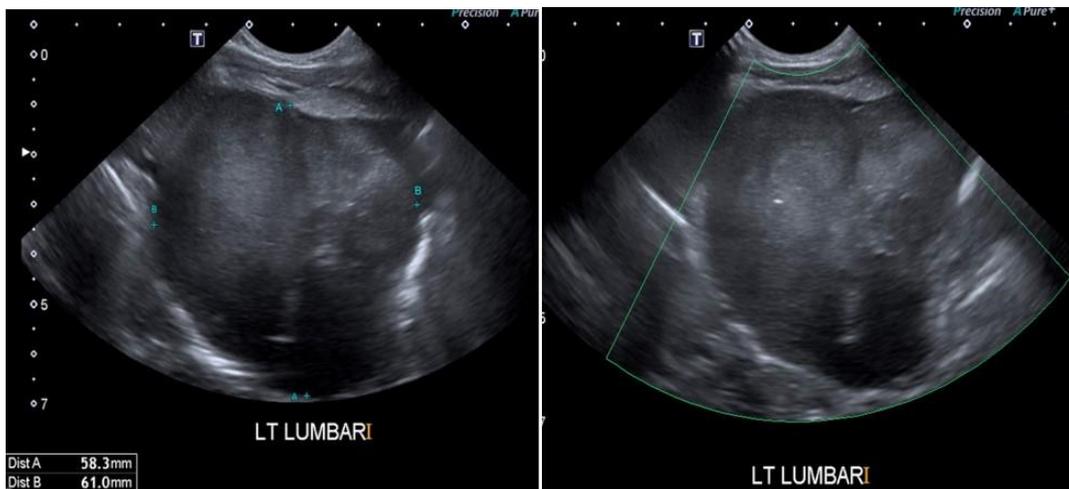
Ultrasound abdomen showed a lobulated hypoechoic solid mass seen at left lumbar region with no vascularity seen within. Some areas of calcification seen within the mass
